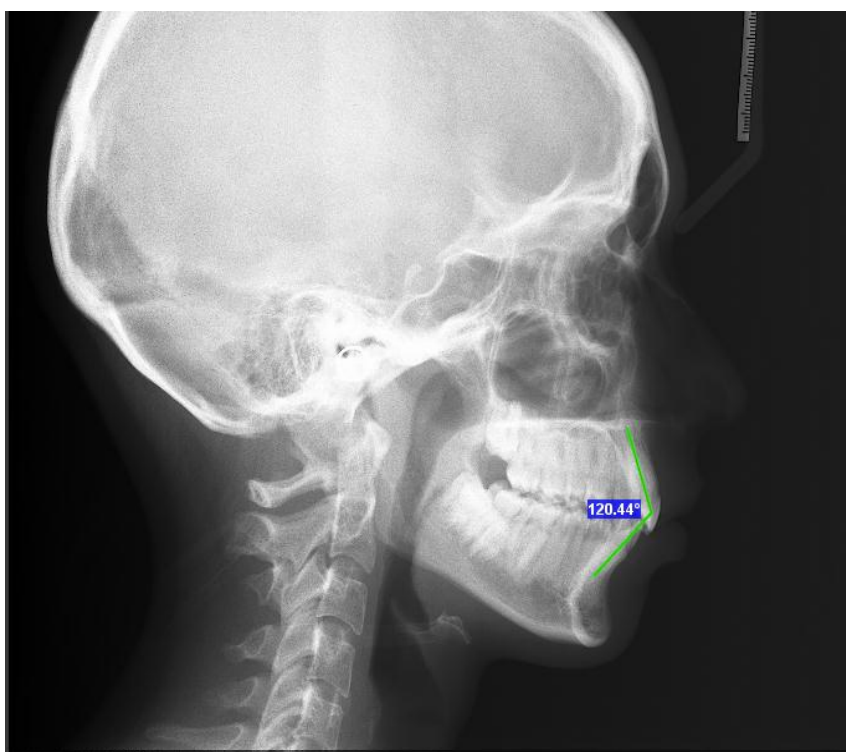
Lateral cephalometric radiograph showing the measurement of Interincisal angle
